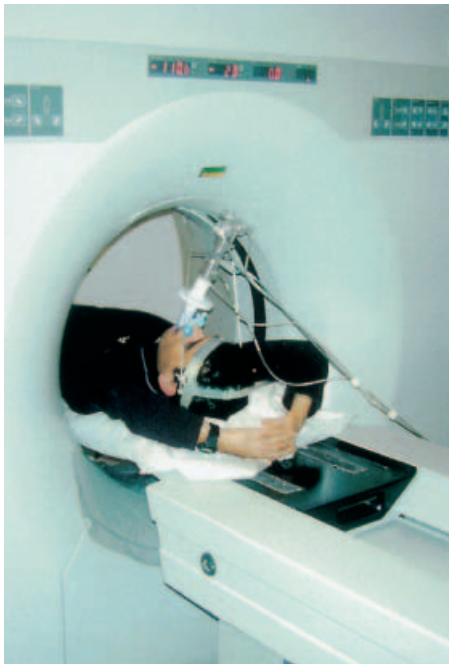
Spirometrically triggered CT. View of a patient breathing through a small spirometer while positioned on the CT scan table
